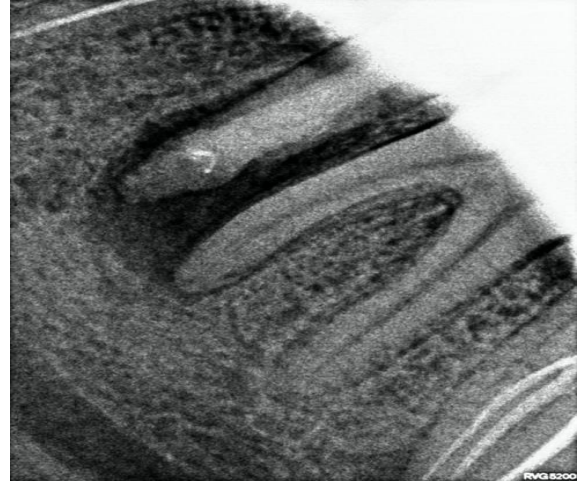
Postoperative periapical radiograph of left side mandibular second premolar after 4 months
